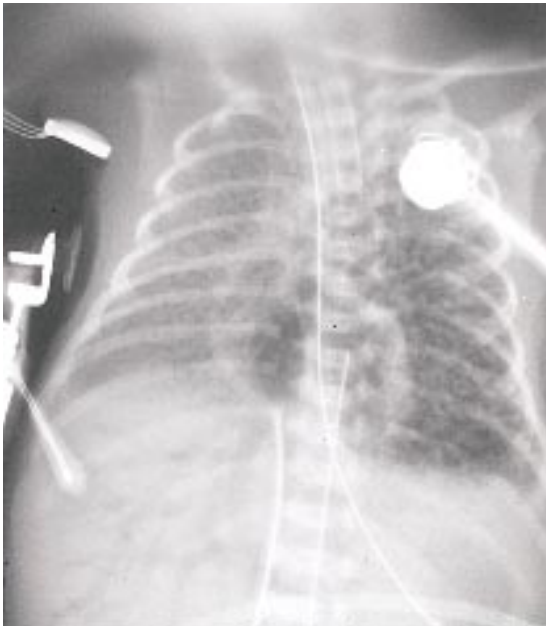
Radiograph in an infant with massive air embolism. Note the presence of air in the heart and in the vascular bed of the liver.
